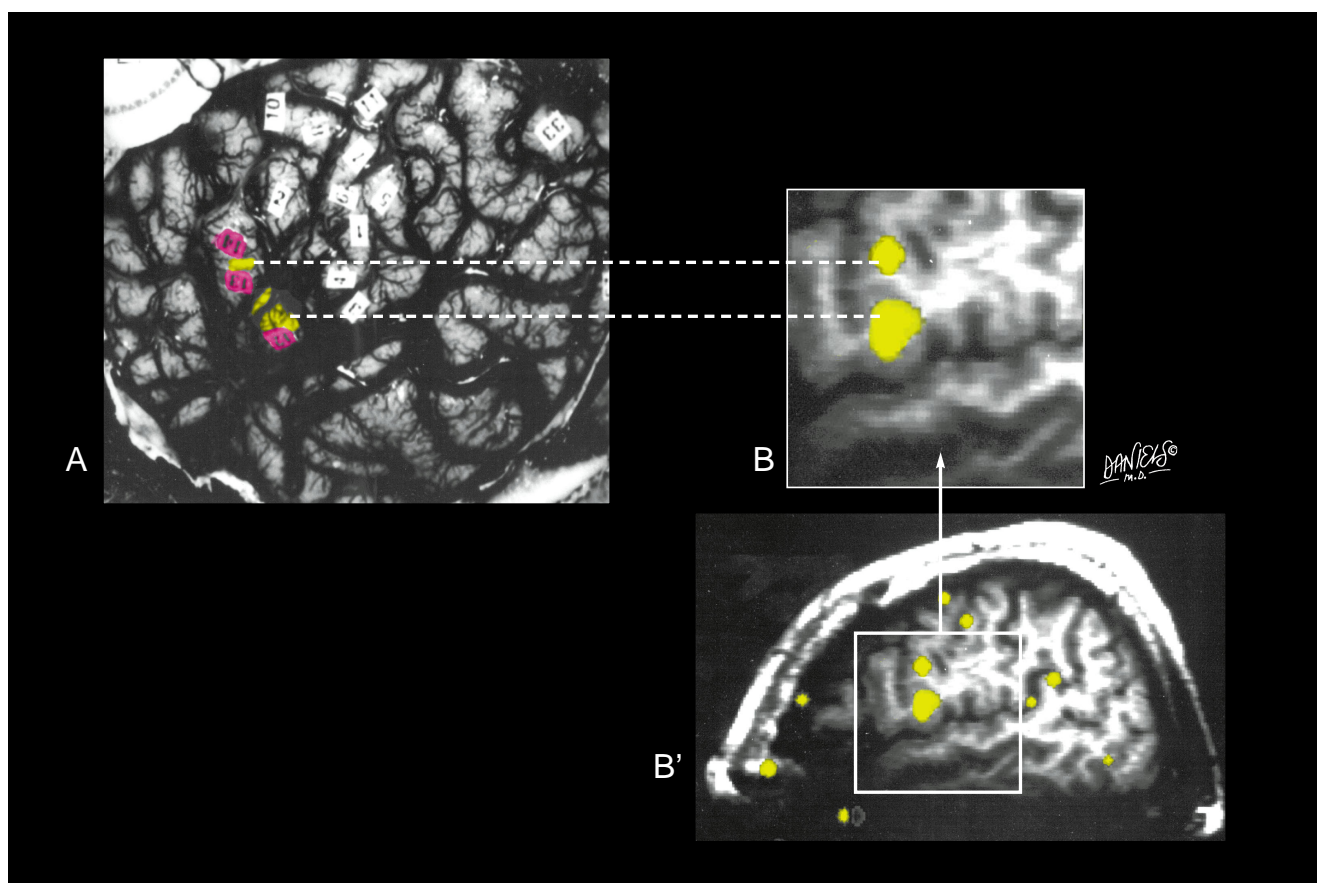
Comparison of a photographic recording of intraoperative mapping (A) and a functional MR image (B') in a patient with epilepsy. The sylvian fissure is evident in both. In the photograph, 12, 13, and 14 represent locations at which stimulation interrupted the patient's speaking. In the functional MR image, the cortical activation from the silent word generation task is shown. After scaling (B) the functional MR image and superimposing it on the photograph, the location of activation is seen to overlap markers 12 and 13.
